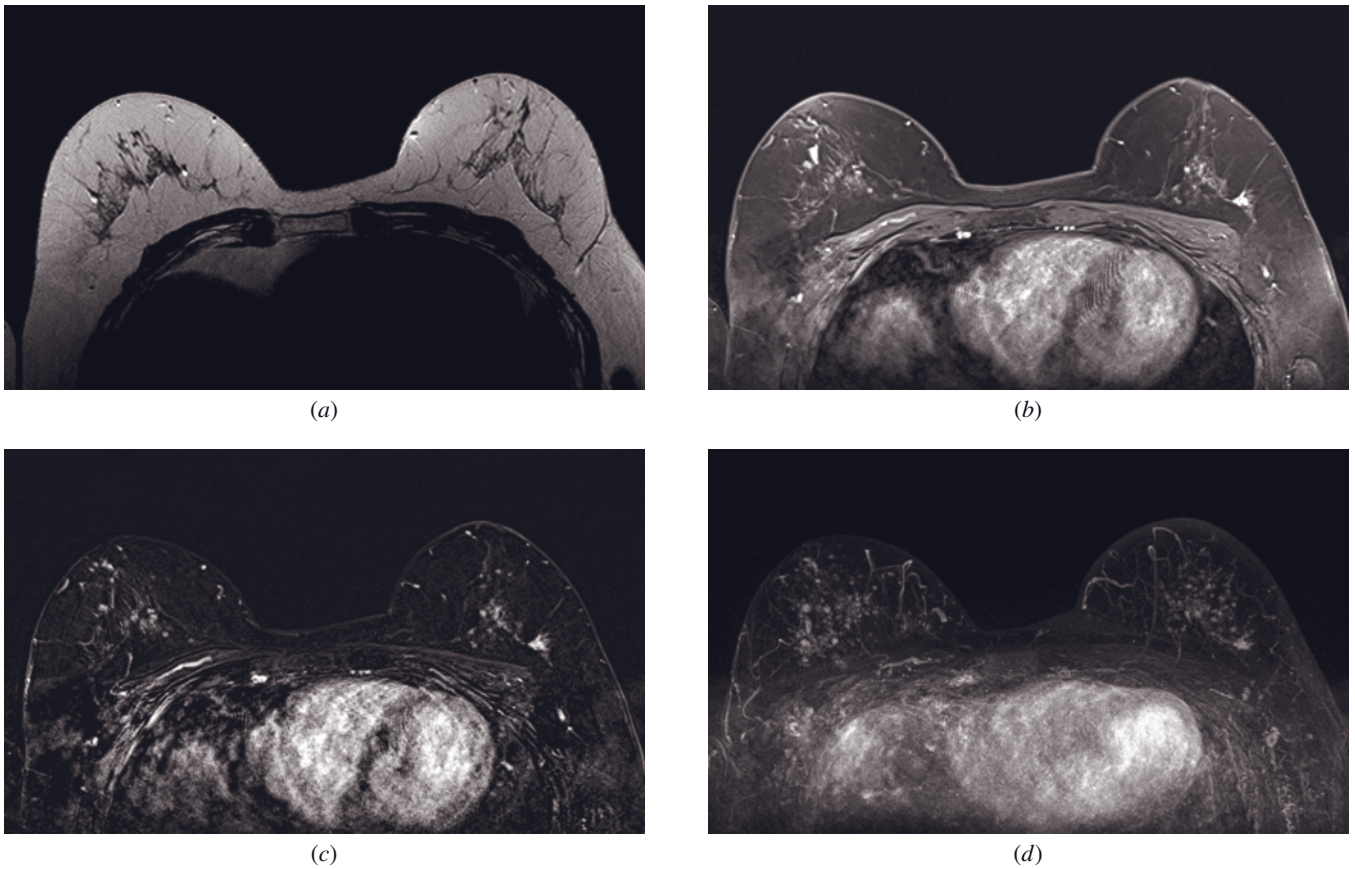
Lobular carcinoma in situ (LCIS). Axial T2-weighted image (*a*) shows a hypointense stellate lesion in the lateral part of the left breast with moderate enhancement on the postcontrast dynamic GRE (*b*) and subtracted (*c*) images. MIP image (*d*) indicates many additional enhancing foci symmetrically distributed in both breasts. Analysis of the dynamic data set shows a washout
